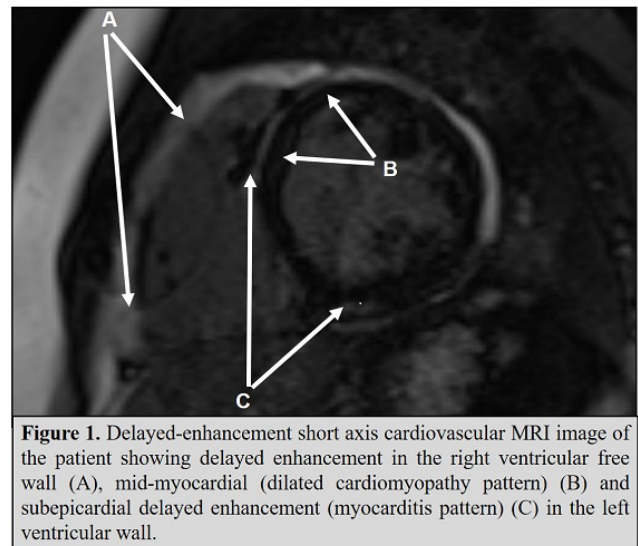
Short axis cardiac MRI image
